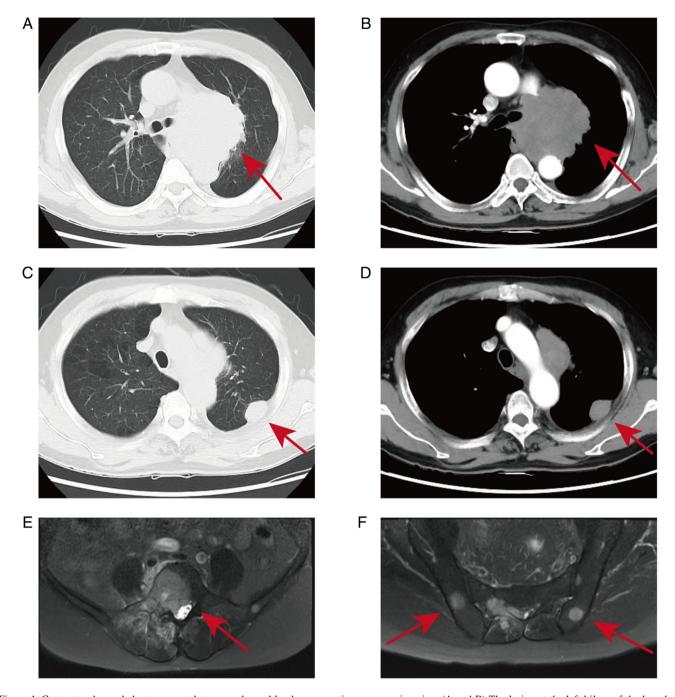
Contrast-enhanced chest computed tomography and lumbar magnetic resonance imaging. (A and B) The lesion at the left hilum of the lung has merged with the lymph nodes in zones 3P, 6 and 7, with a maximum diameter of \sim 83 mm (Red arrow). The trachea at the left hilum of the lung has been compressed and narrowed. (C and D) A soft tissue-like lesion is visible near the pleura in the dorsal segment of the left middle lung. It has a well-defined boundary and dimensions of \sim 24.9x18.5 mm (Red arrow). (E and F) Abnormal signals were detected in the vertebral body and bilateral ilium (Red arrow).
